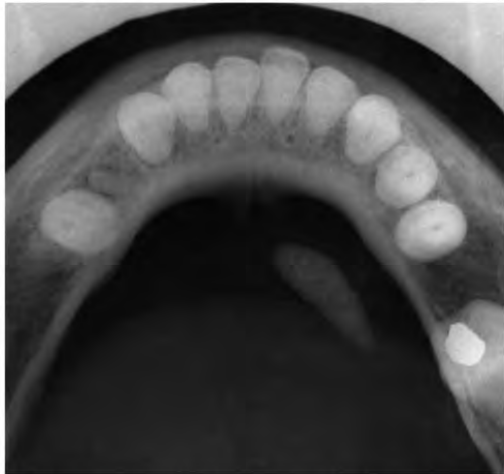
Trans-occlusal endoral radiography showed a radiopaque formation within the Wharton's right duct.
